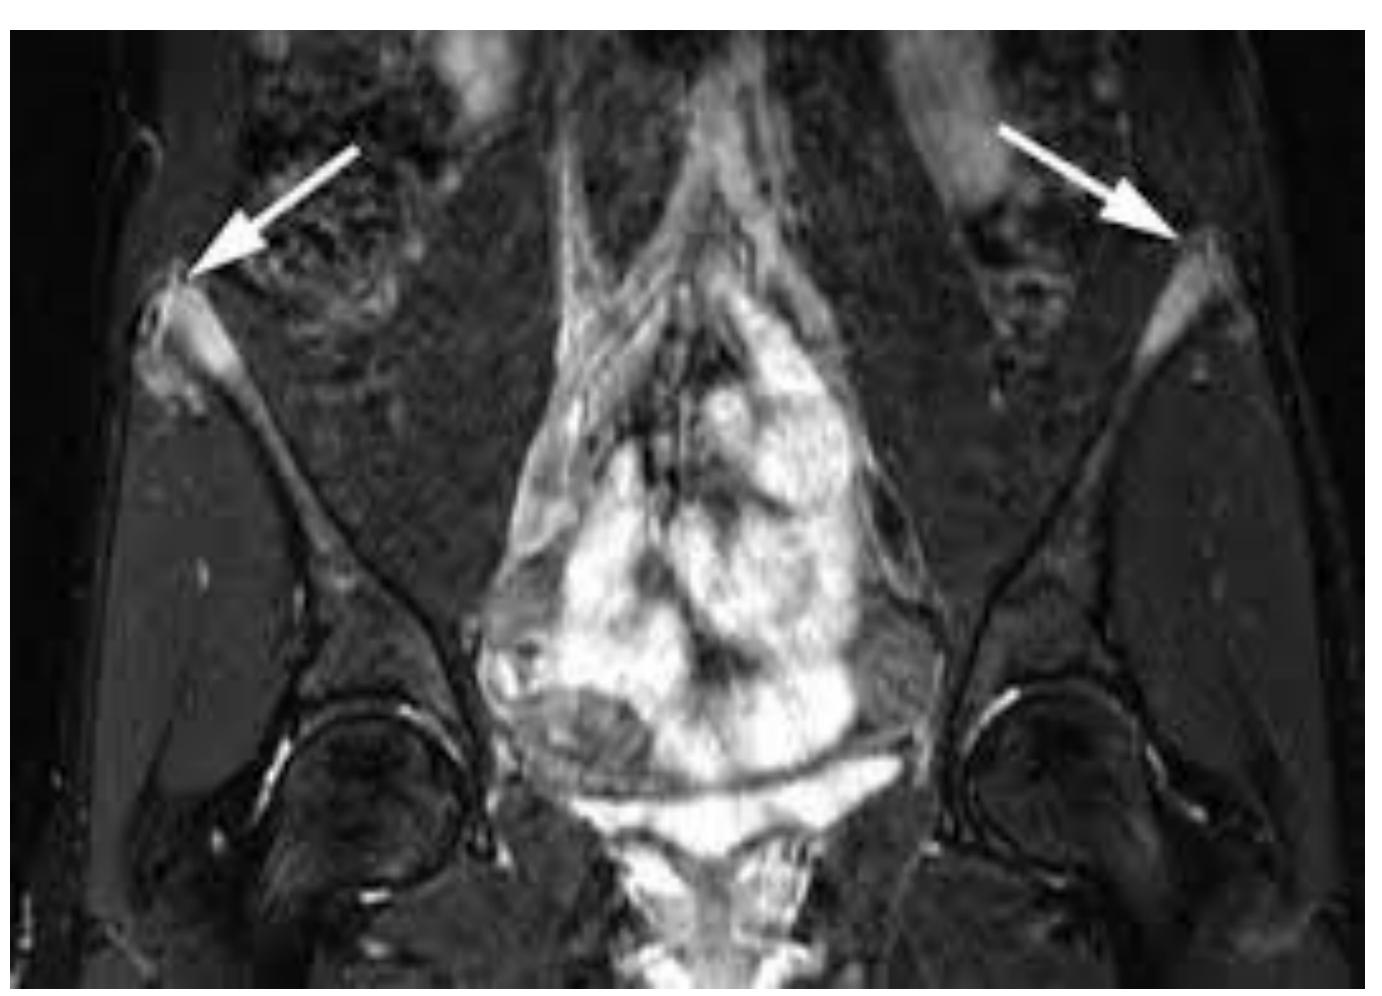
MRI example of ASIS inflammation. Arrow points to inflamed Iliac crest and ASIS prominence (not from patient).³
